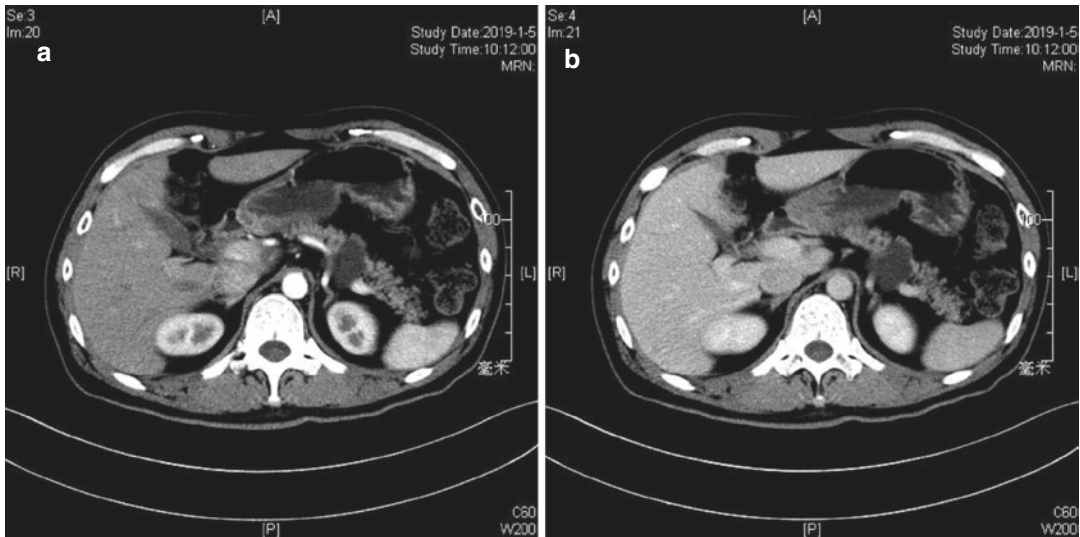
(a, b) Arterial and venous phase of abdominal CT
